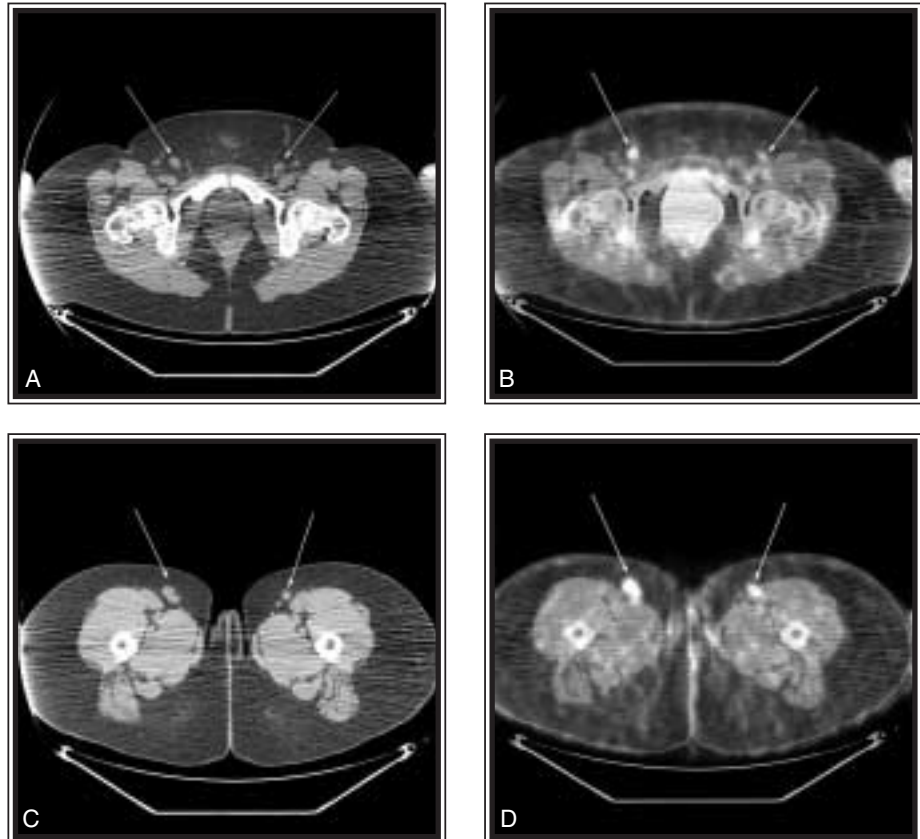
A: Axial unenhanced CT obtained as part of the PET/CT in a 36-year-old woman with a past history of melanoma in the right lower extremity. The arrows point to slightly prominent bilateral inguinal nodes. B: Axial fused PET/CT image demonstrates that these inguinal nodes have increased FDG uptake. C: Axial unenhanced CT obtained as part of the PET/CT with the arrows pointing to slightly prominent bilateral infrainguinal nodes. D: Axial fused PET/CT image demonstrates that these infrainguinal nodes have increased FDG uptake. This PET/CT was read as being concerning for the inguinal and infrainguinal node uptake. An ultrasound-guided biopsy of one of the infrainguinal nodes demonstrated results consistent with a reactive node. A follow-up PET/CT in three months demonstrated decreased FDG uptake in these regions. This is an example of a false-positive result on PET imaging.
